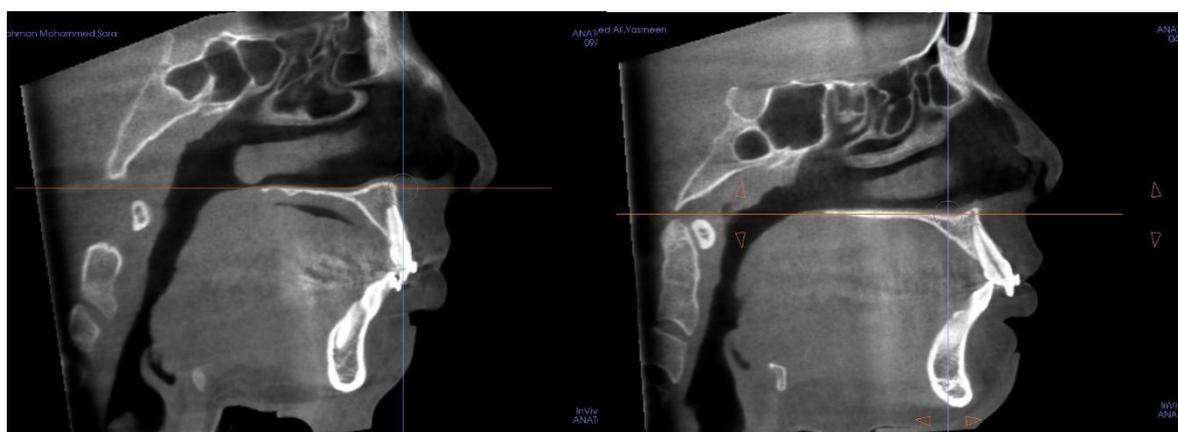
Example of CBCT axial slice ready for measurements.
